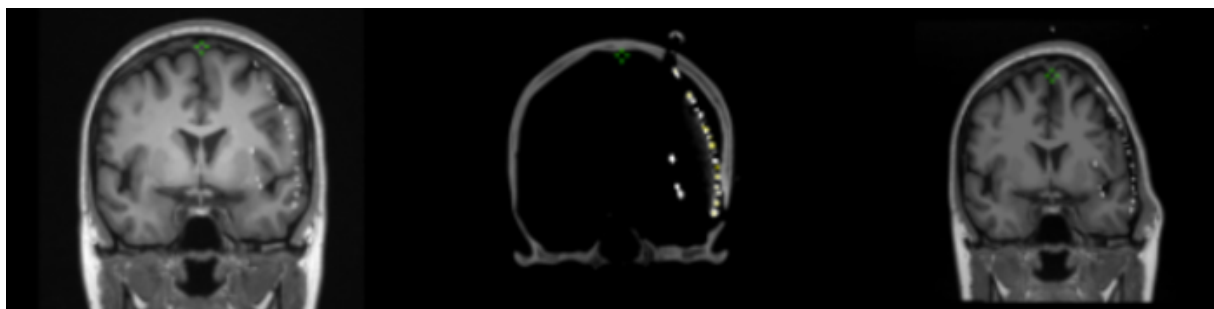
MRI (left, right) with electrodes from CT (middle) before transformation on left and after transformation on the right
